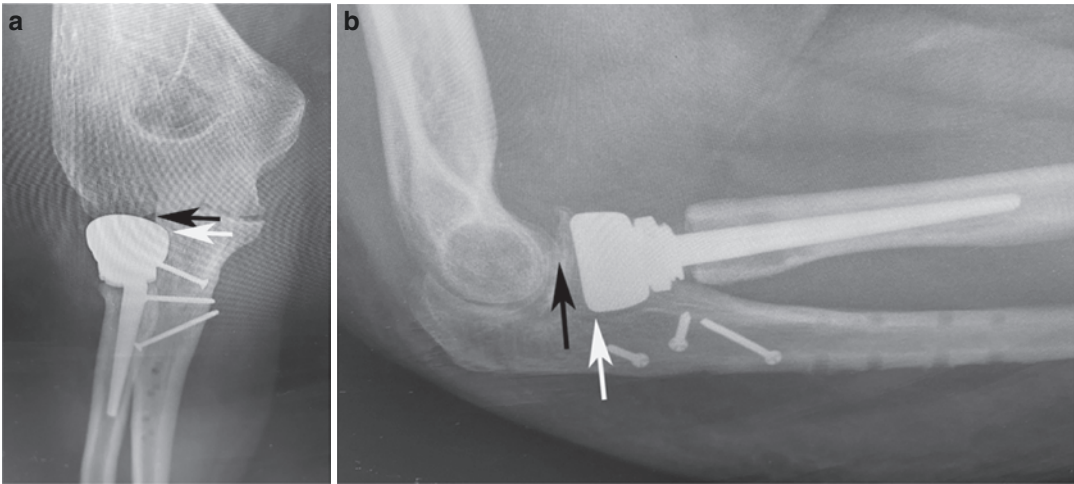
(a–b) Anteroposterior (a) and lateral (b) radiographs of a shortened radial head implant (white arrow) placed shorter than the proximal margin of the lateral coronoid facet (black arrow)
